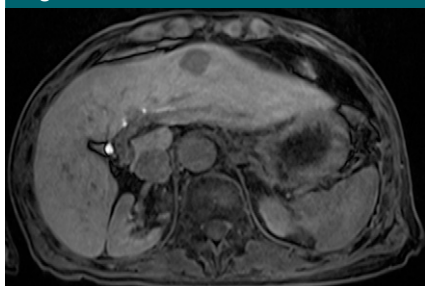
Patient 4. Axial 3D GRE T1-weighted MR image with fat suppression (3.5/1.42; flip angle, 15°) at 20 minutes after gadoxetate disodium administration obtained in a 73-year-old man with hepatocellular carcinoma. The contrast between the liver and spleen is low. Surrounding liver was proved to be cirrhotic at surgical resection. HUI was low (0.203 L) consistent with a low ICG-PDR (0.082 sec⁻¹).
